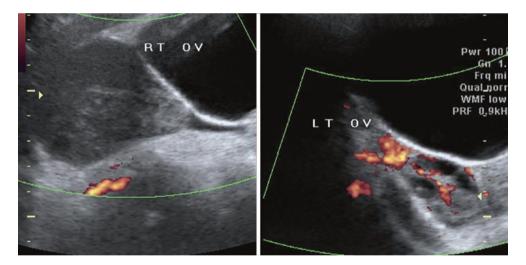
Doppler assessment in a patient with right ovarian torsion, using the normal left ovary as a control. No flow is seen in the torsed right ovary, and good flow is seen in the normal contralateral ovary
